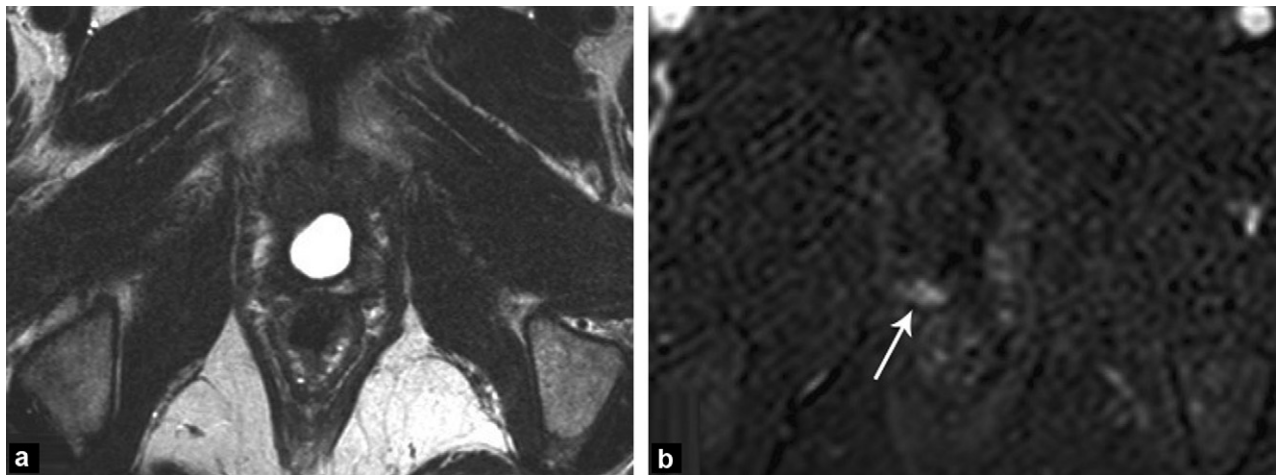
A 57-year-old patient who had had a prostatectomy 3 years previously for a Gleason 7 prostatic adenocarcinoma. After surgery, the PSA nadir was 0 ng/mL. Gradual increase again to 0.32 ng/mL: a: T2-weighted axial magnetic resonance imaging (MRI) shows no abnormality; b: the dynamic axial slice subtracted after injection of contrast agent detected early enhancement of the right side of the neck of the bladder (arrow); targeted biopsies showed a Gleason 7 adenocarcinoma.
